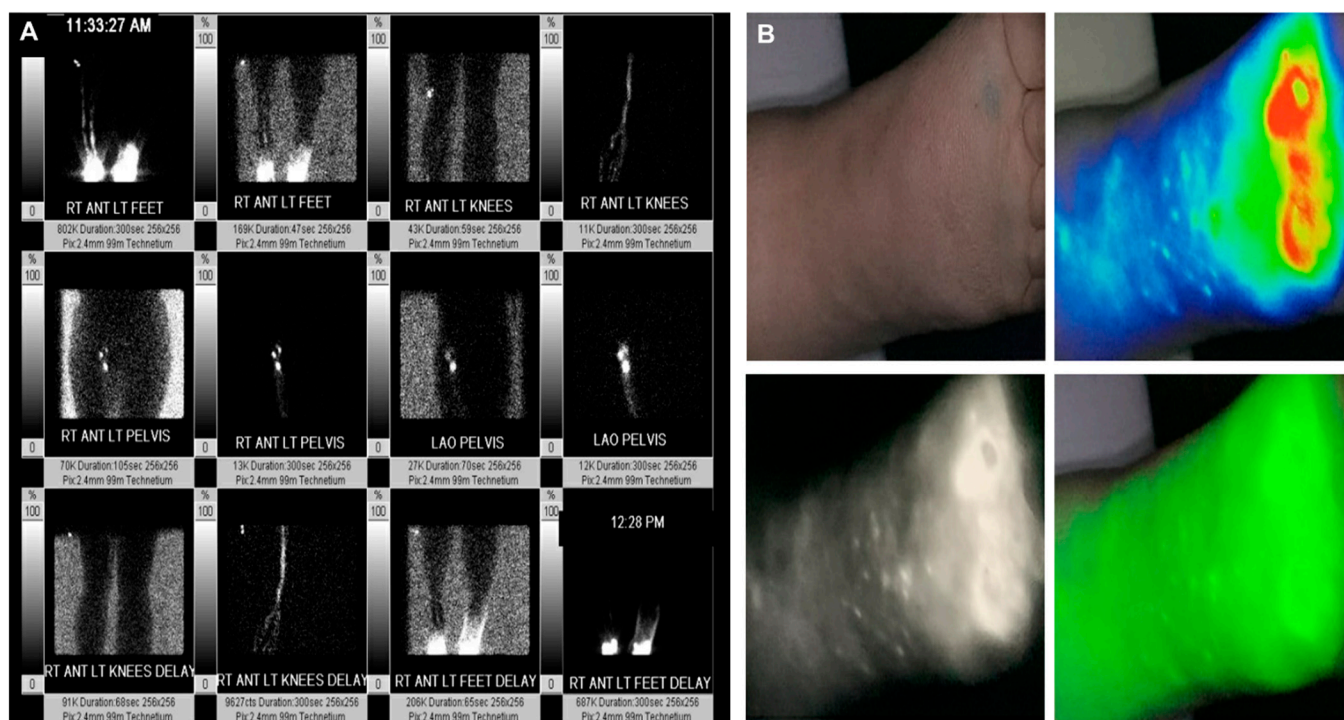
(A) Lymphoscintigram of the lower limbs in a patient with lymphedema showing channels, tortuosity of channels and dermal backflow. (B) Lower extremity indocyanine green lymphography showing a diffuse pattern at the toes with a stardust pattern at the dorsum of the foot.
